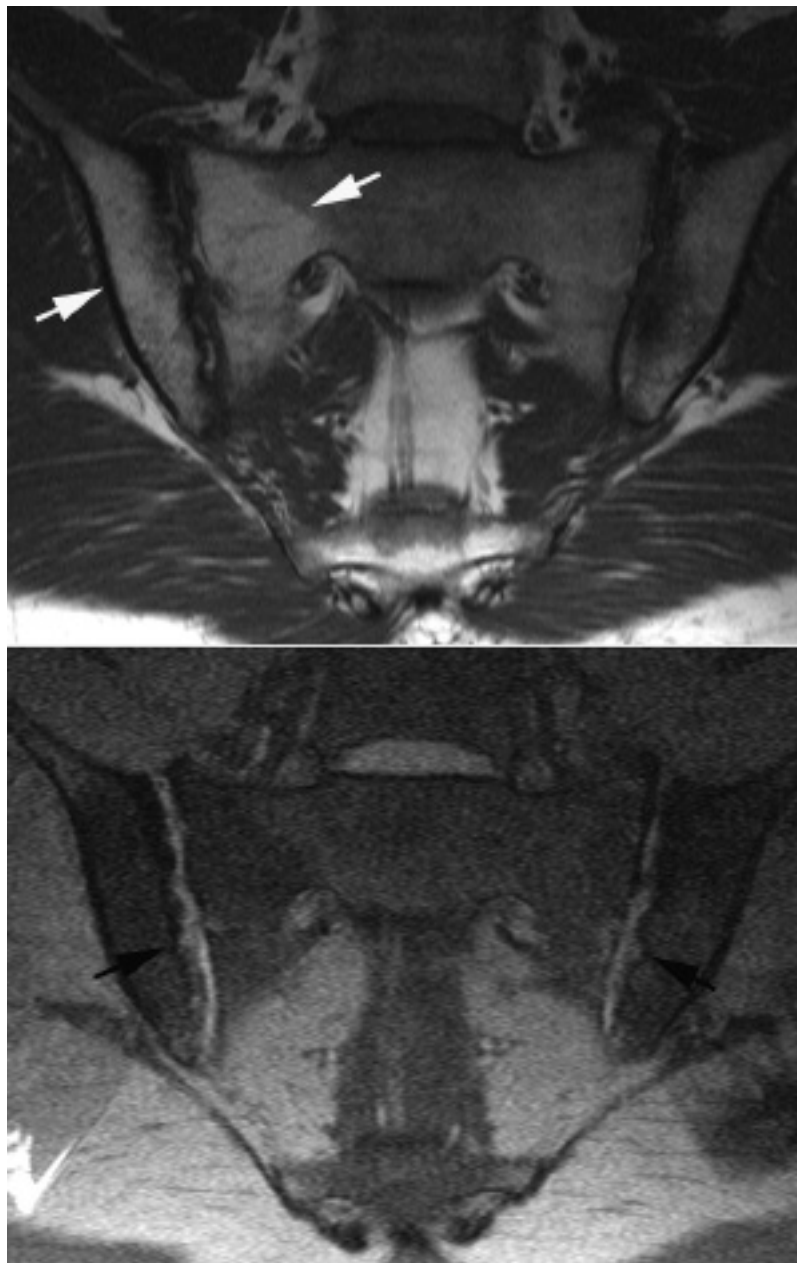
Followup magnetic resonance imaging, 5 years later: semicoronal T1 (upper image) and T1 fat-saturated images showing pronounced chronic changes in the form of bilateral erosion (black arrows) and fatty marrow deposition (white arrows).
